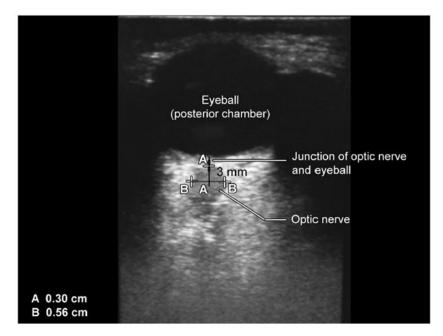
Sonographic image of optic nerve and eyeball. For measurement of optic nerve sheath diameter (ONSD) a 3 mm line (A-A) is drawn from junction of eyeball and optic nerve. At this point another line is drawn perpendicular to the first line (B-B) to measure the ONSD.
